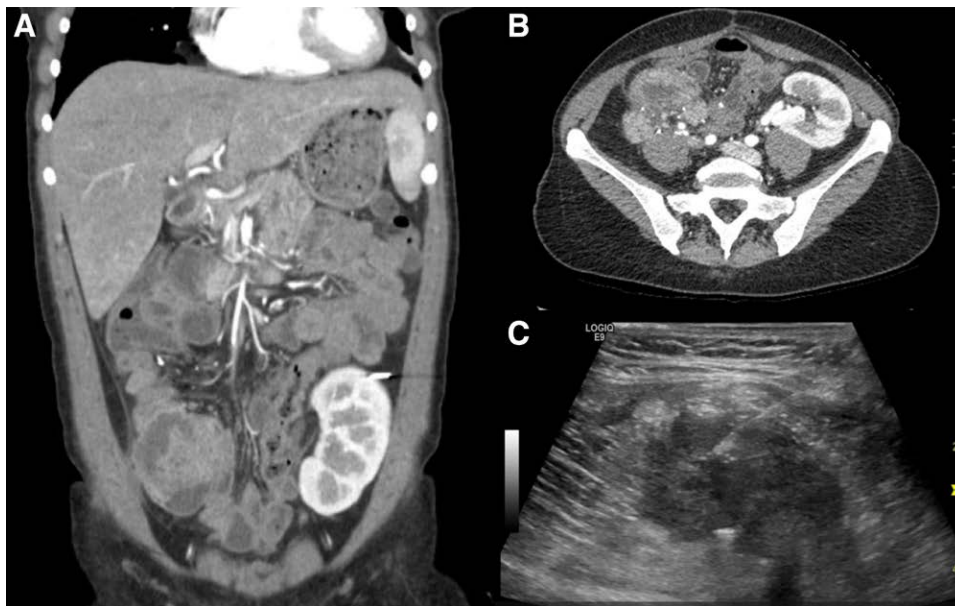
Images of the lesion associated with the allograft pancreas in the right lower quadrant in case 2. A, Coronal CT scan. B, Axial CT scan. C, Successful ultrasound-guided fine-needle aspiration of the lesion in the transplanted duodenum associated with the allograft pancreas. CT, computed tomography.
